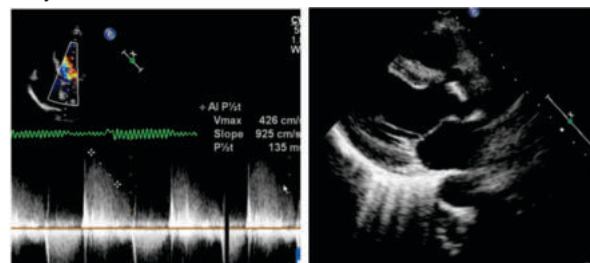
a) Transthoracic doppler signal showing severe aortic regurgitation b) Transthoracic echo showing large vegetation over aortic valve
